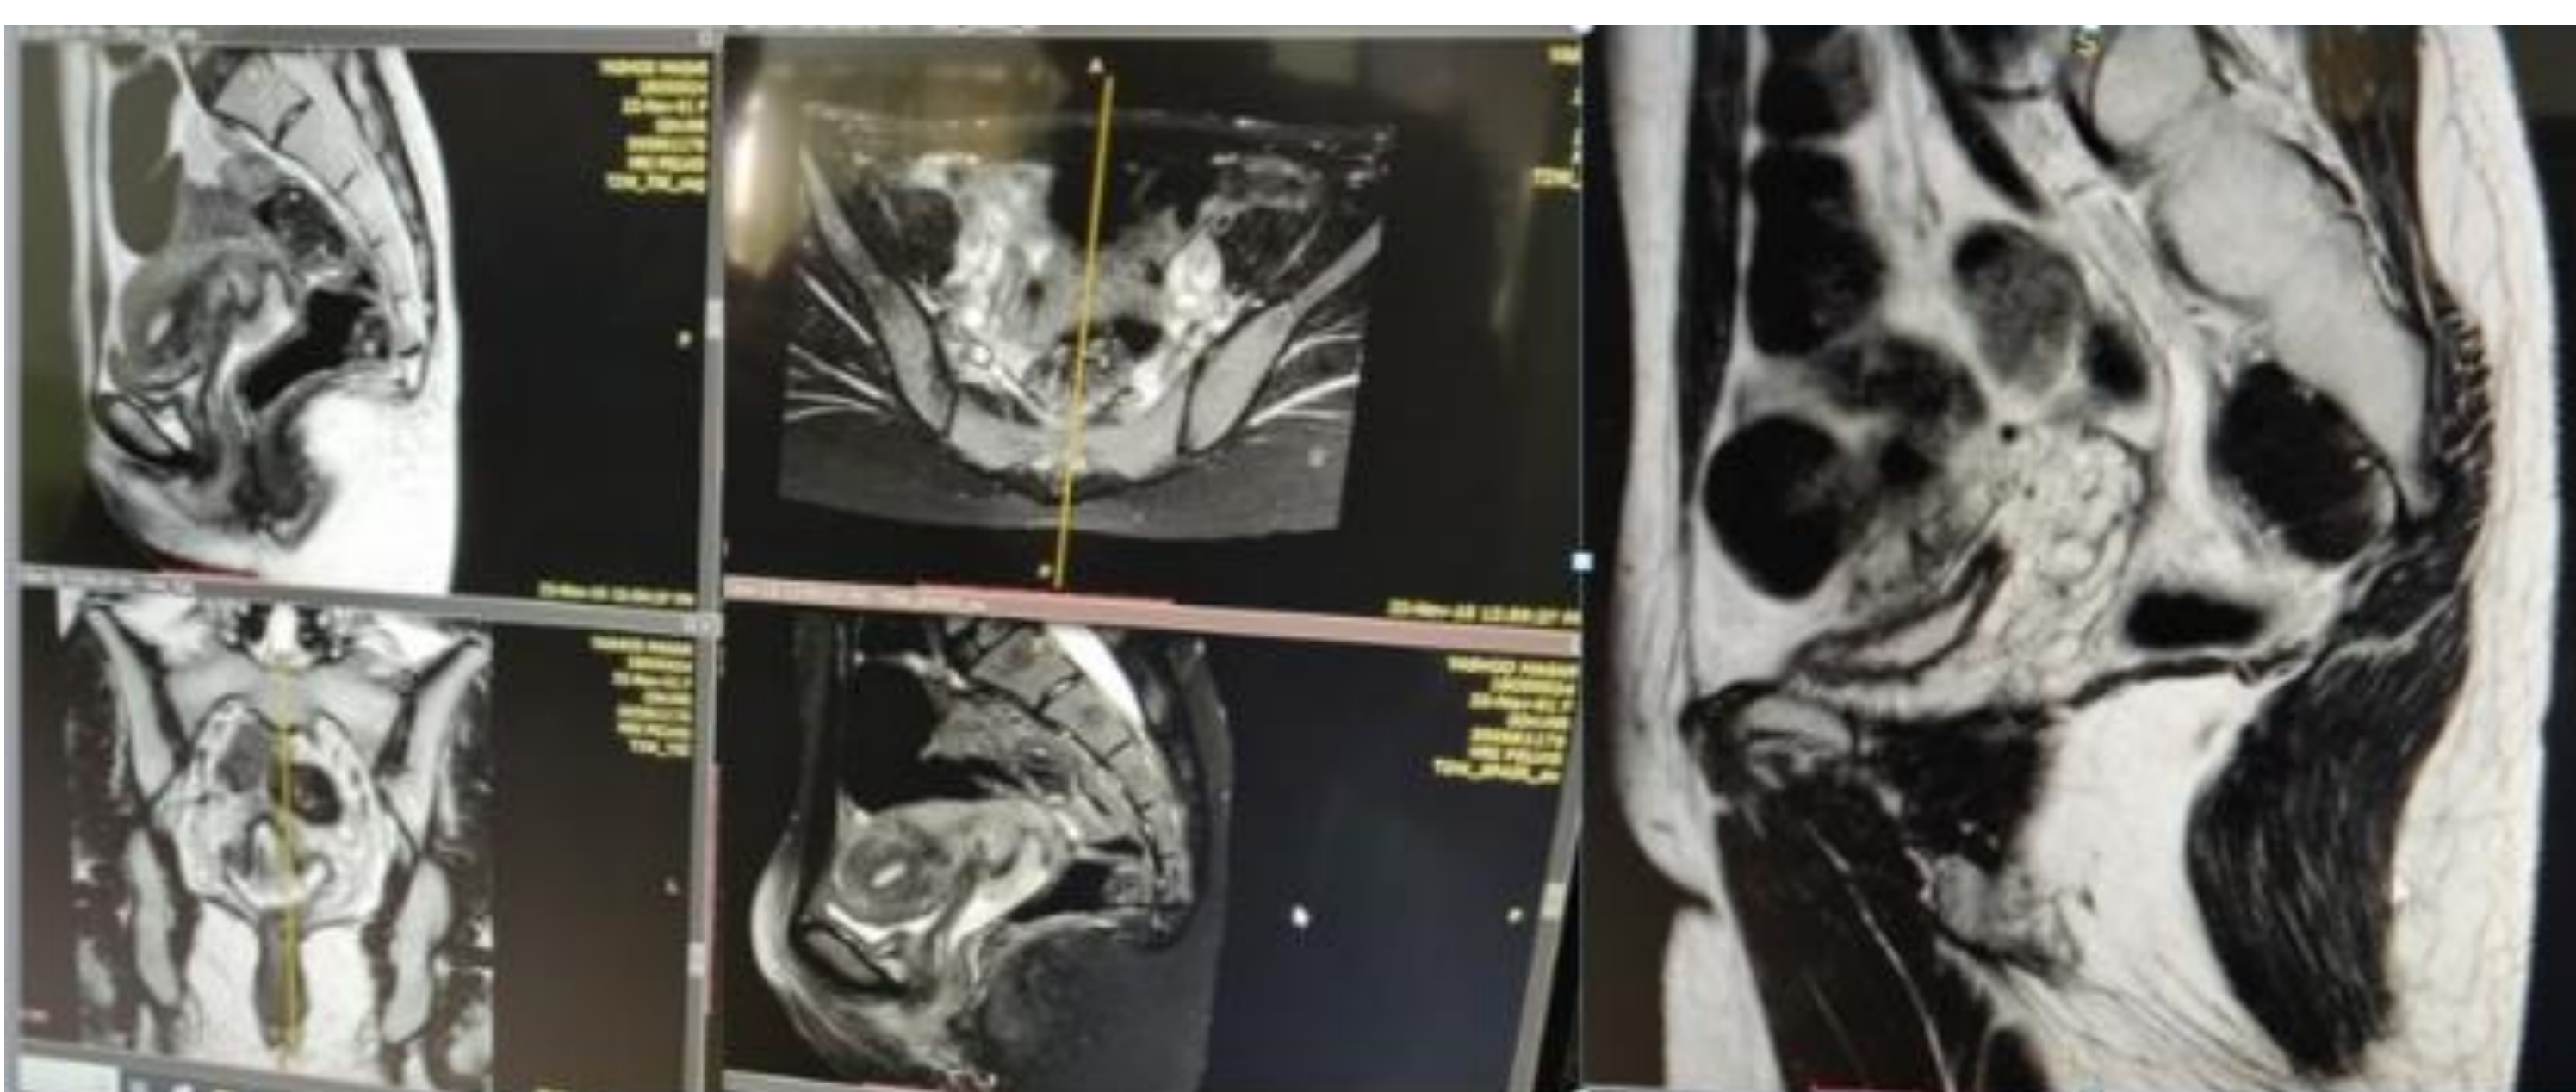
MRI pelvis shows Lobulated cystic lesion displaying iso to low signal in T1 and high signal in T2 and fat suppressed images noted in cervical canal and upper part of vaginal canal measuring 6.5x 5.3 cm in size. Cervical stroma is normal. Rest of the uterus shows normal morphology and signal intensity.
